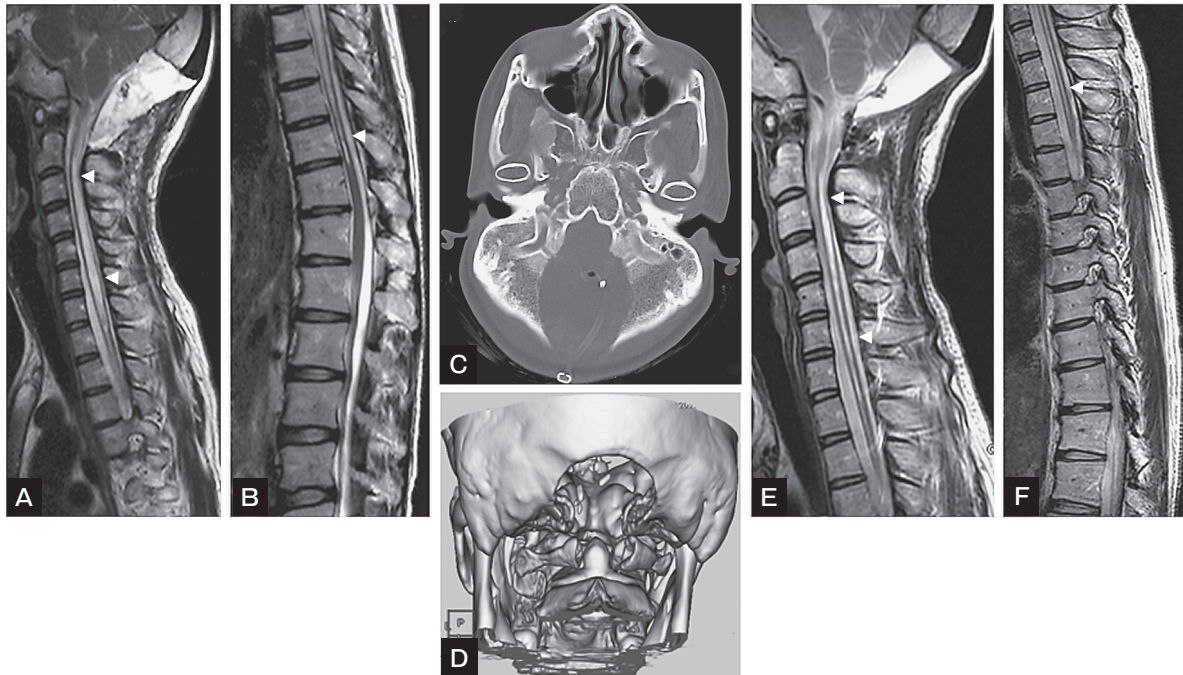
Postoperative neuroradiological images T2-weighted images on MRI demonstrated shrinkage of the syrinx at 7 days and 3 months after the surgery (arrowheads, A, B & E, F). Plain CT revealed that the normal venous drainage through the jugular foramen was preserved (C). 3D-CT showed the area of the FMD and C1 laminectomy (D).
